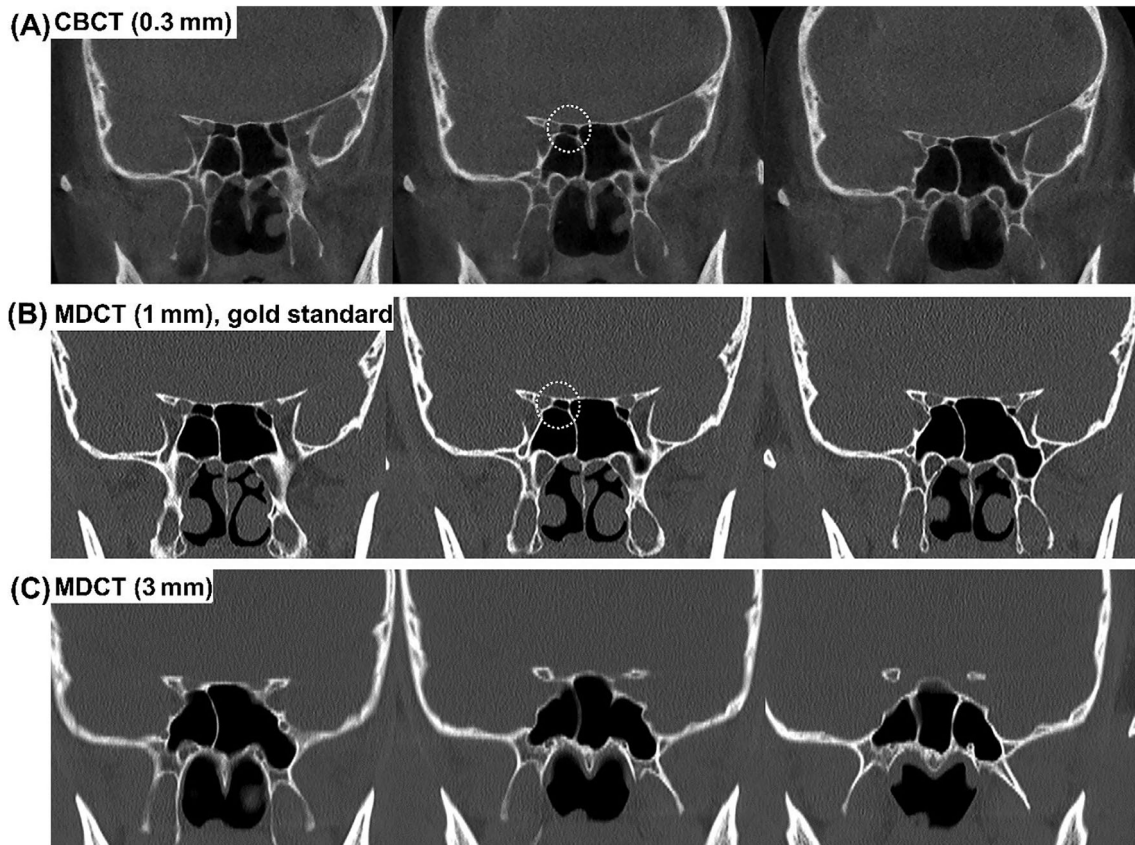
Onodi cells (inside the dashed circle) on the right side are identified on (A) CBCT with 0.3 mm thickness and (B) MDCT with 1 mm thickness, but not on (C) MDCT with 3 mm thickness. CBCT, cone-beam computed tomography; MDCT, multi-detector computed tomography
